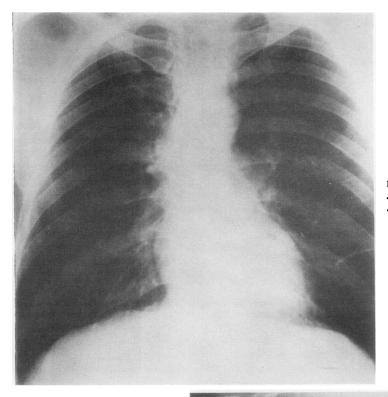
Case 1. Chest radiograph showing considerable diminution of shadowing after six weeks' treatment.
